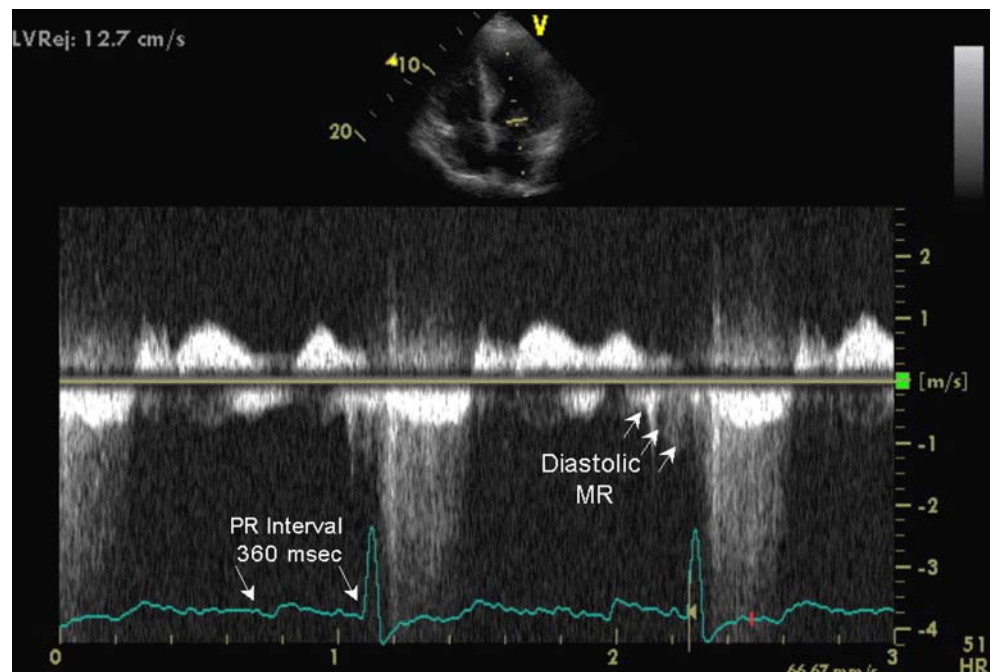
Continuous-wave Doppler echocardiographic recording of transmitral blood flow velocity demonstrating diastolic mitral regurgitation in a patient with first-degree AV block with a markedly prolonged PR interval of 360 ms. The low velocity regurgitant signal is seen in diastole following the atrial filling wave and prior to the onset of systolic mitral regurgitation
